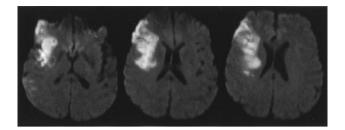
DWI from 1 patient with a large right-hemisphere lesion and low NIHSS score. Patient presented with neglect and minimal weakness (NIHSS=5).
